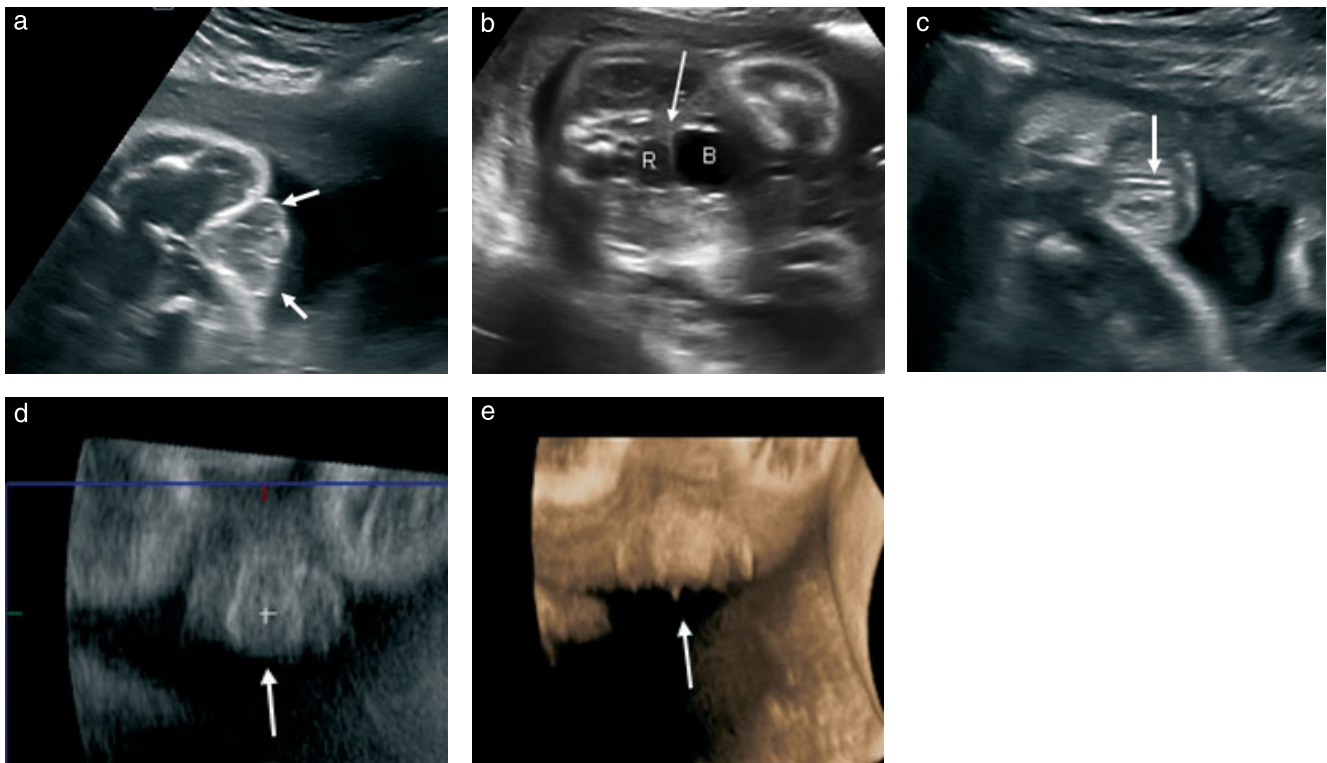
Imaging in a case of hypospadias at 29 weeks' gestation in a male fetus with severe early onset intrauterine growth restriction. Addition of an internal genitalia view in combination with the pregnancy history helped to confirm male gender. At delivery, micturition occurred at the penoscrotal junction, consistent with Grade 3 hypospadias with penoscrotal transposition. (a–c) Transverse ultrasound images demonstrating ambiguous genitalia. (a) Three structures create the 'tulip' sign, with the short penile shaft nestled between the bifid scrotum (arrows). (b) The thin echogenic line (arrow) is the short rectovesical distance creating a flat interface with the bladder (B) consistent with male internal genitalia. R, rectum. (c) The urethra is visualized as an echogenic line (arrow) ending along the base/shaft of the short penis, consistent with hypospadias. (d) Coronal reconstruction image demonstrating the micropenis with bulbous ending and downward direction between the bifid scrotum (arrow). (e) Volume-rendered coronal image demonstrating downward direction of the micropenis (arrow).
